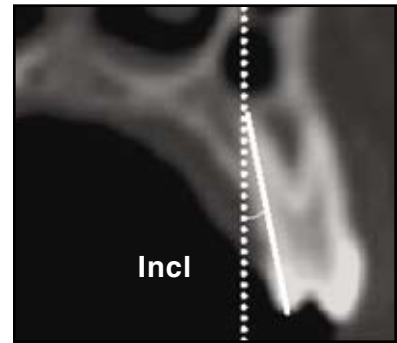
Measurement of tooth inclination (Incl), corresponding to angle between line perpendicular to lower border of CT image and line passing through palatal cusp tip and palatal root apex.
